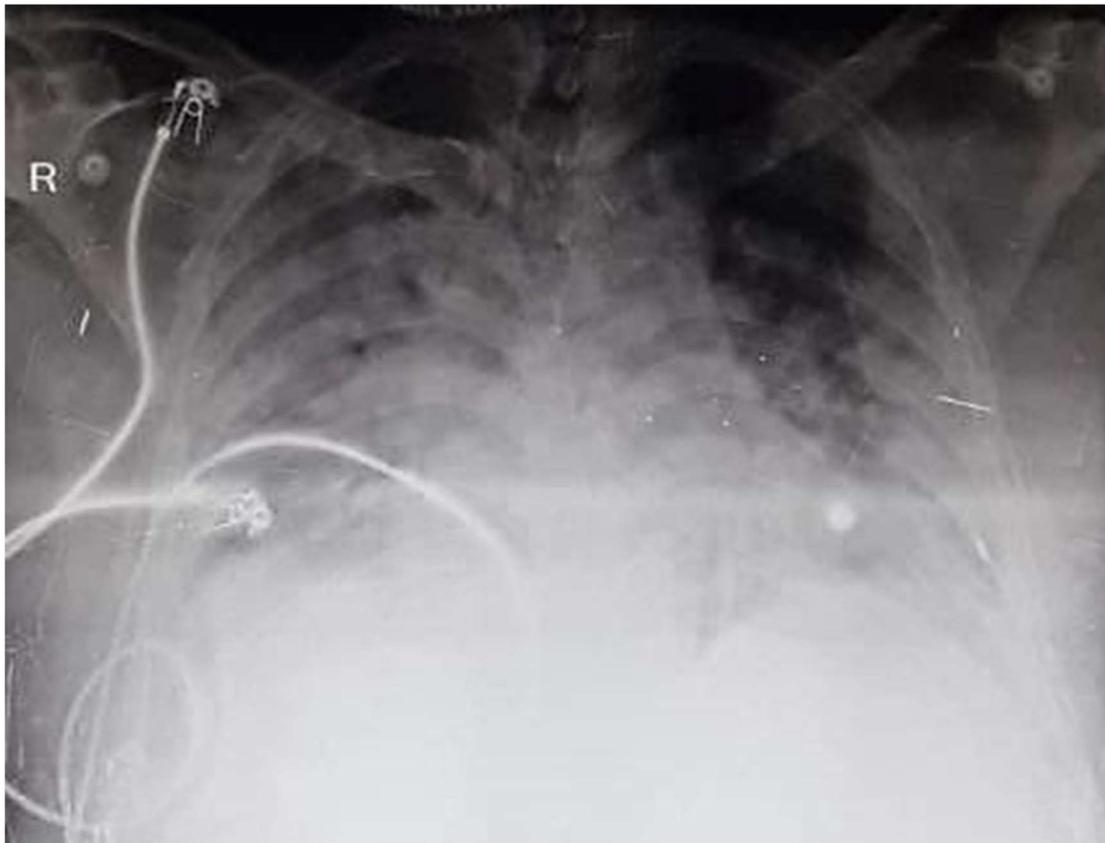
Baseline anterior-posterior view (AP) chest radiographs of case 3.
